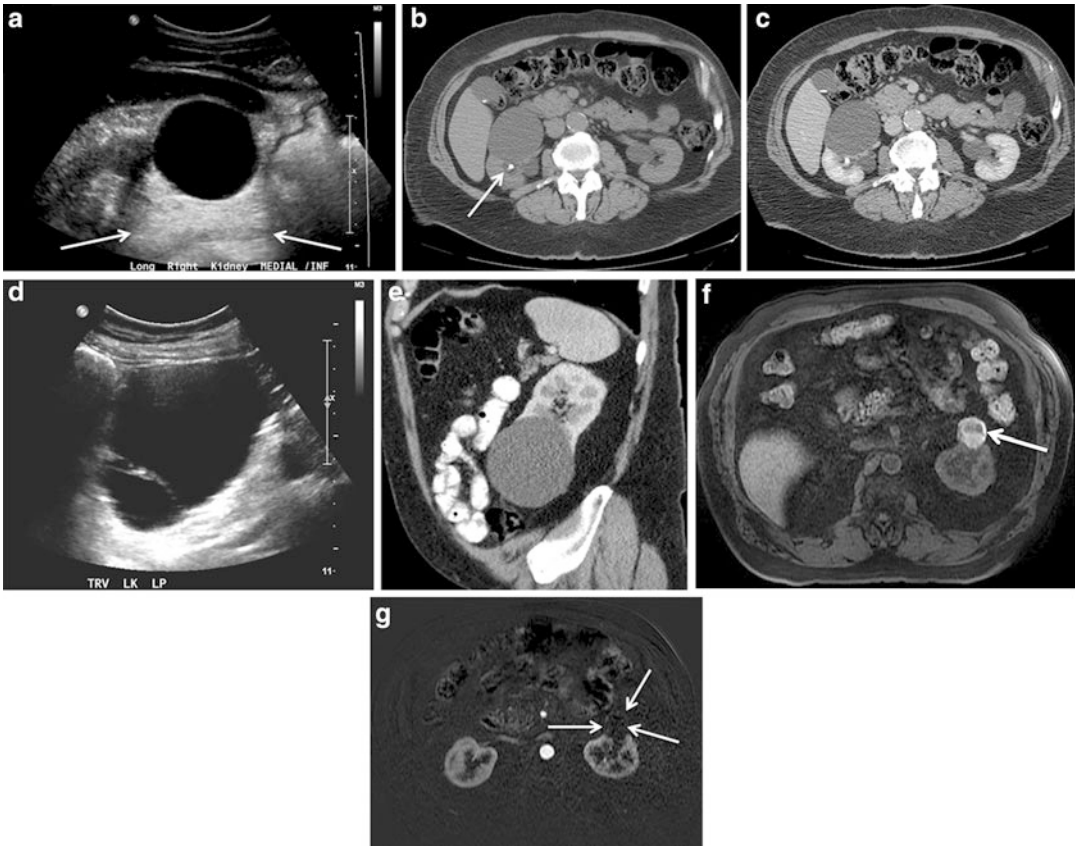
Imaging of simple and complicated renal cysts. (a) Longitudinal sonographic image of the left kidney reveals a simple, unilocular, exophytic, uniformly anechoic cyst with acoustic enhancement (arrows) and an imperceptible wall. (b) The unenhanced CT image shows uniform fluid hypodensity within the cyst with an adjacent nonobstructing calculus (arrow). (c) The postcontrast CT image demonstrates absent enhancement within the cyst. (d) Transverse sonographic image in a different patient shows a large left renal cystic lesion with an irregular
